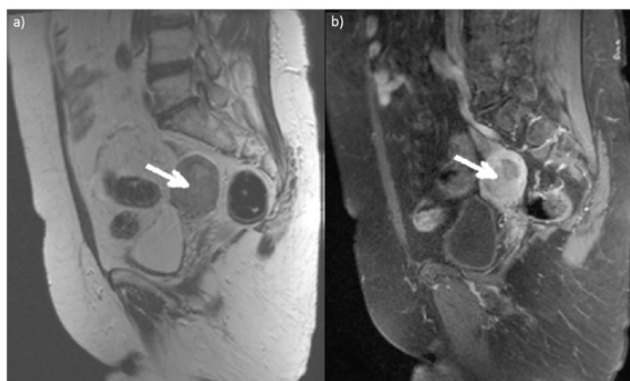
Pelvic MRI: a) T2W and b) T1W C+ images show endometrial carcinoma with infiltration of myometrium > 50% (arrows); complete loss of the junctional zone (stage Ib).
